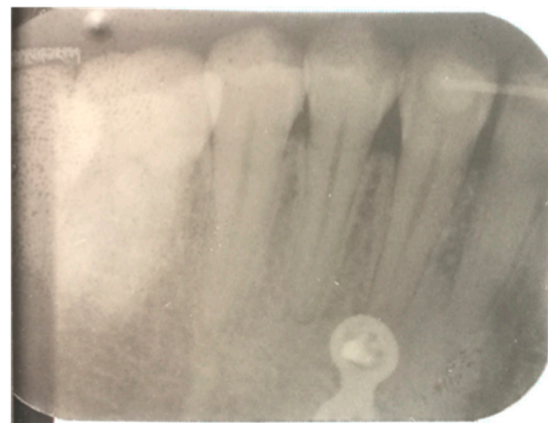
The same patient, four years after BSSO surgery, x-ray performed because of odontalgia of element 4.3 in contact with the synthesis media.
